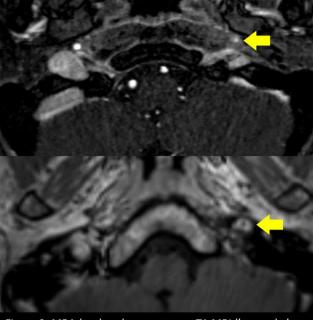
MRA (top) and post-contrast T1 MRI (bottom) show narrowing of the left ICA with a thickened and enhancing wall
